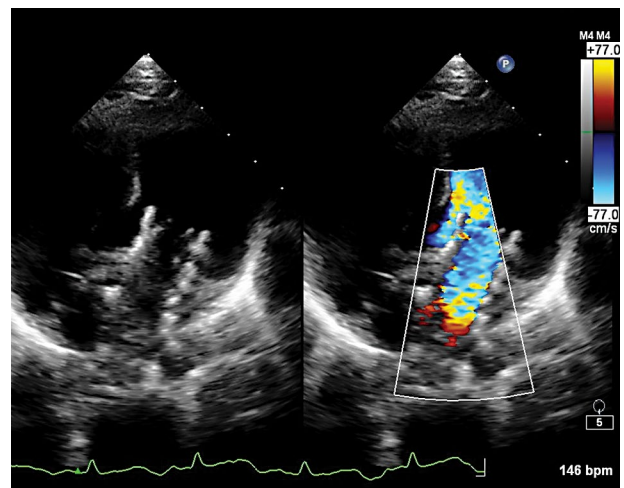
There was some residual paravalvular flow from the ventricular side with communication to the left atrium, which closed spontaneously — regular control transthoracic echocardiography examination performed before the discharge
